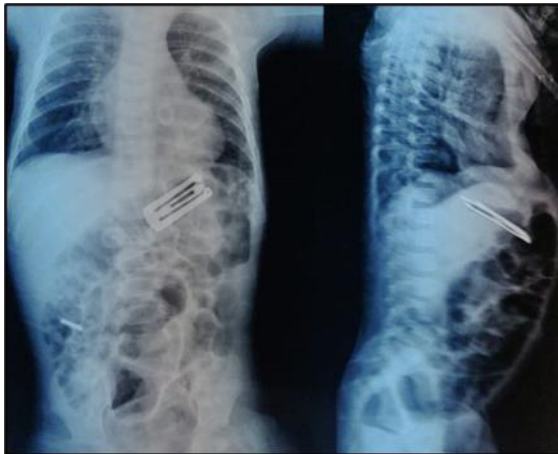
X-ray chest and abdomen showing impacted foreign body (tik-tak hair clip) in abdomen.
